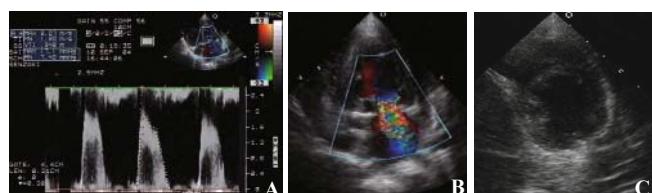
A: pulse Doppler finding indicating mitral stenosis; B: color Doppler finding indicating mitral regurgitation; C: Short axis view demonstrating only slightly compressed inter-ventricular septum (arrows).
